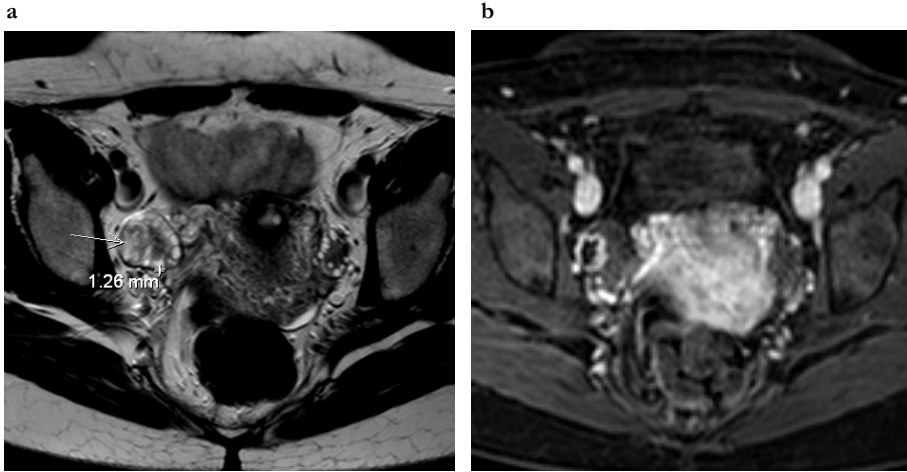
T2-weighted TSE (a) and contrast enhanced fat-suppressed GE (b) MRI acquisitions in the transaxial plane. The arrow indicates a star-like corpus luteum with intense peripheral contrast enhancement in a polycystic ovary. The 1.26 mm measurement is on a low-in-signal-intensity peripheral rim on the T2-weighted scan.
